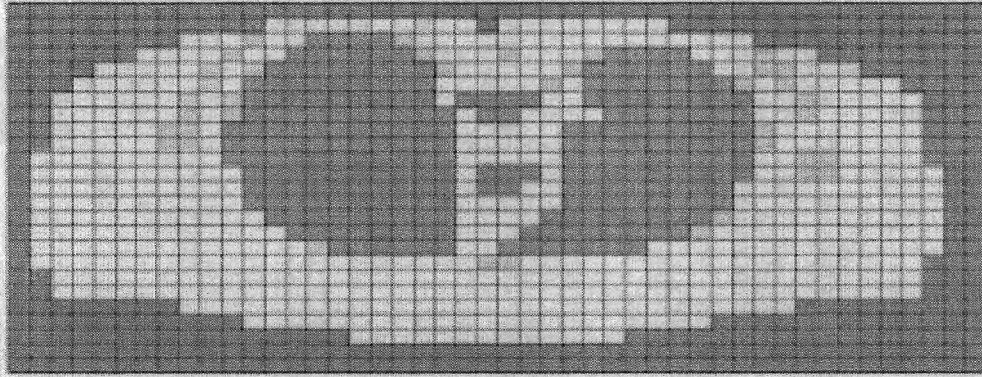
Coarse CT Slice Depiction – Red (Air), Yellow (Tissue), Purple (Lung Tissue), Green (Bone)
